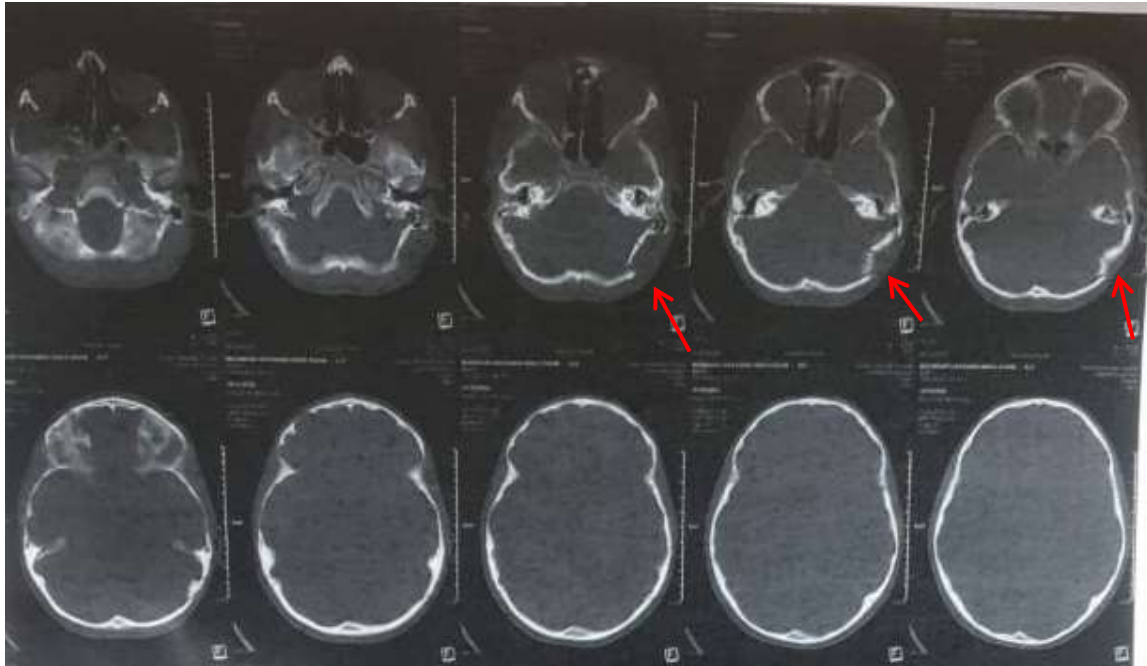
CT bone window axial cuts showing left basal occipital depressed fracture , red arrow showing location of depressed fracture.
